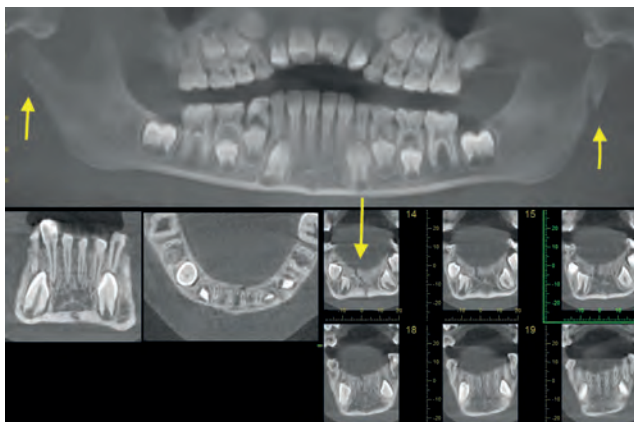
Fragment of CBCT of pat. S., 9 y.o. on admission. Diagnosis: "Traumatic bilateral triple mandibular fracture; in the left and right condylar area and symphysis without fragments displacement. Traumatic intrusive dislocation of 11,21 teeth (Fracture lines are indicated by arrows).
